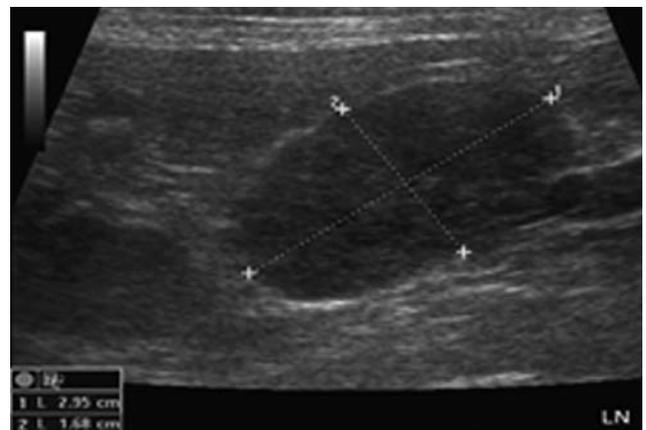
Longitudinal ultrasound image of a lymphomatous abdominal lymph node. Note the enlarged size, the rounded shape and the hypoechoic parenchyma of the lymph node.
